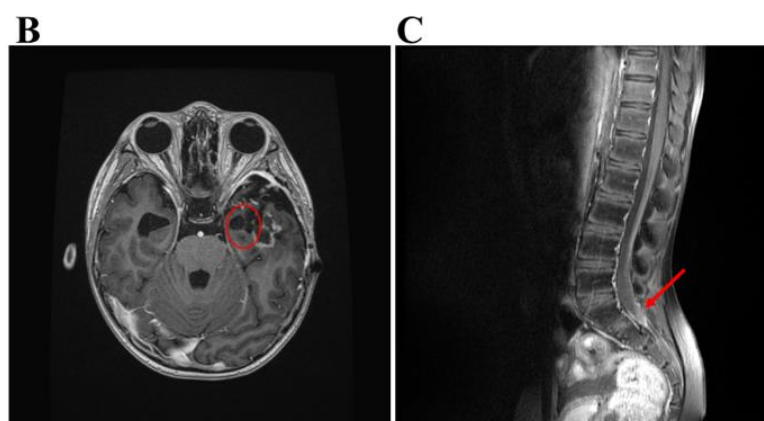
The MRI images at various stages throughout the tumor progression. B) The MRI scans conducted post-treatment in April 2021, showed a satisfactory level of tumor control. C) The tumor presented with spinal seeding in March 2022. The tumor regions are highlighted with a red circle or arrow.
